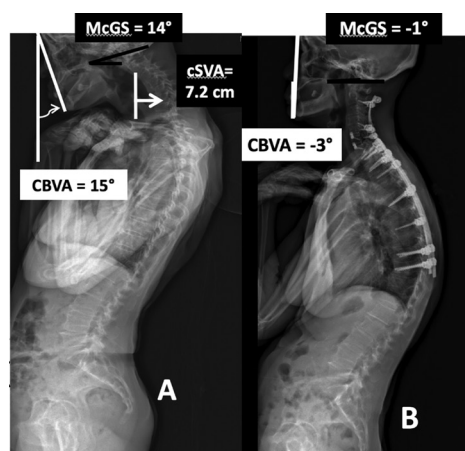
Preoperative (A) X-rays of a patient with severe cervical deformity (cSVA >4 cm) with loss of horizontal gaze. Chin Brow Vertical Angle (CBVA) is 15° and the surrogate measure, McGregor's Line Slope (McGS) is 14°. Postoperatively (B) the deformity is corrected and horizontal gaze is restored.
